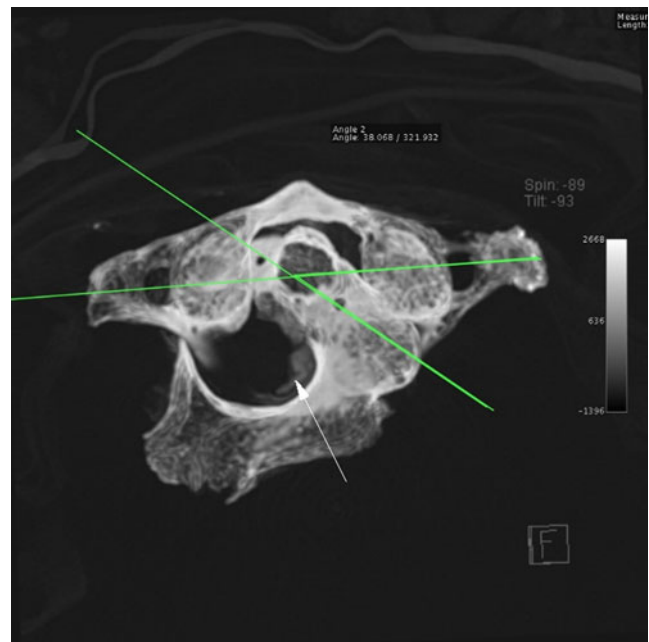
Axial CT scan of atlas and the rotated axis (dislocation angle= 38°). The narrowed bony spinal canal is additionally reduced by hematoma on its left wall (*arrow*)
